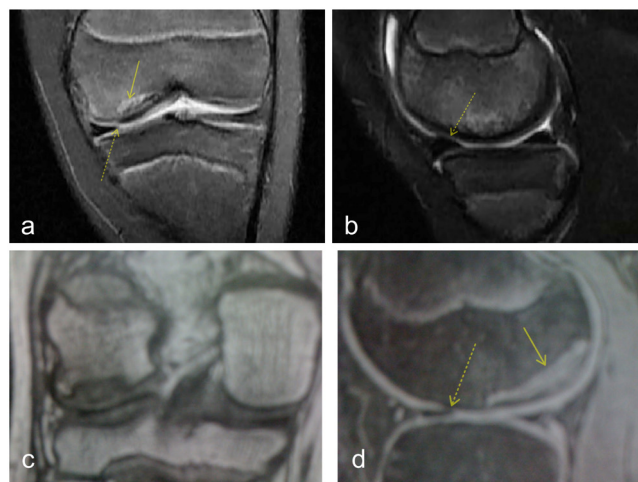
Evaluation of OCD lesion with MRI.
